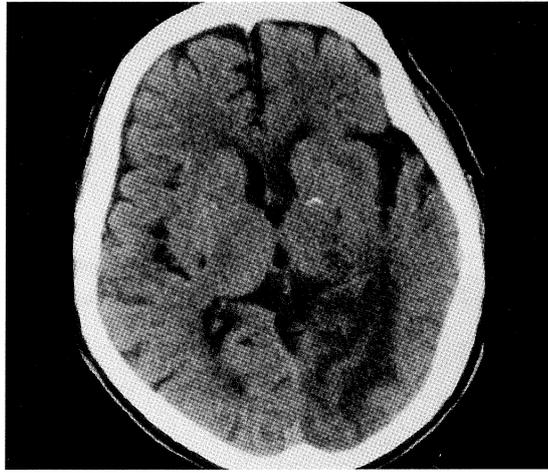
CT scan of the head showing a hypodense lesion in the territory of the left posterior cerebral artery.
